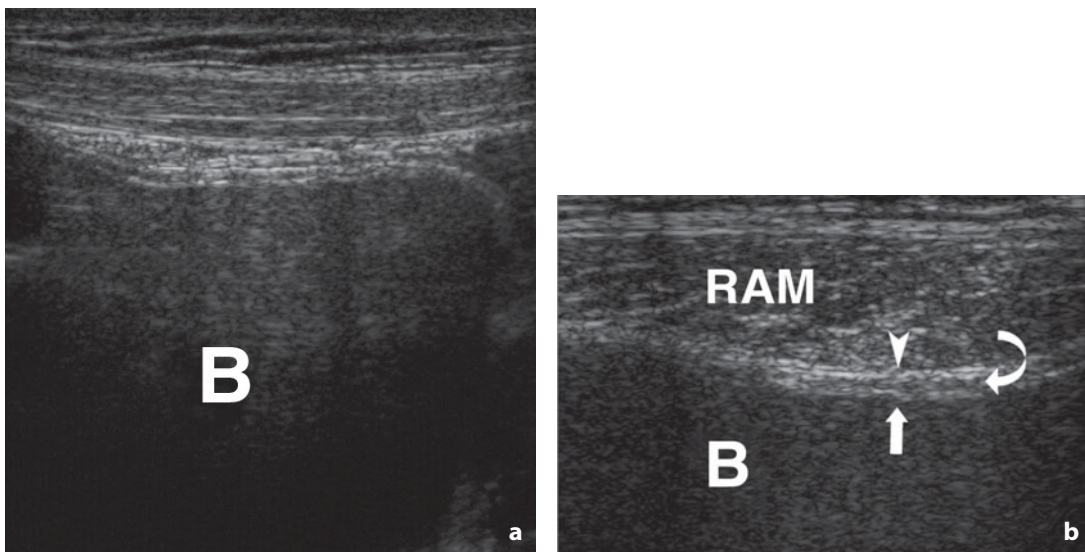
Ultrasonography. Urinary bladder. With the use of a high-frequency transducer the different layers making up the bladder wall can be distinguished, particularly in the detailed image (b): external, hyperechoic, corresponding to the adventitia and the surrounding adipose tissue (*arrowhead*); middle, hypoechoic, corresponding to the muscle coat (*curved arrow*); internal, hyperechoic, corresponding to the submucosa and mucosa (*arrow*). *RAM*, rectus abdominis muscle; *B*, urinary bladder
